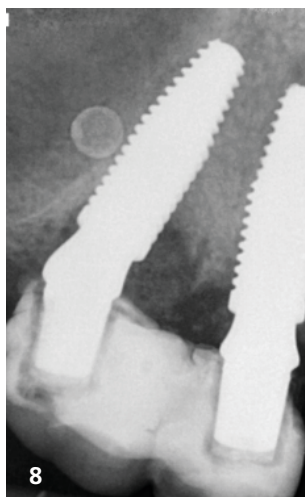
Immediate postoperative with provisional crowns and sutures. – Fig. 8: Immediate postoperative X-ray. – Fig. 9: Four months later, without the temporary crowns and peri-implant health in both implants. – Fig. 10: Occlusal view of the abutments (anterior straight and posterior angled 17 degrees). – Figs. 11a+b: Three-unit fixed prosthesis in lithium disilicate (e.max®). – Fig. 12: Three-unit fixed prosthesis cemented. – Fig. 13: Occlusal view of the final restoration.
